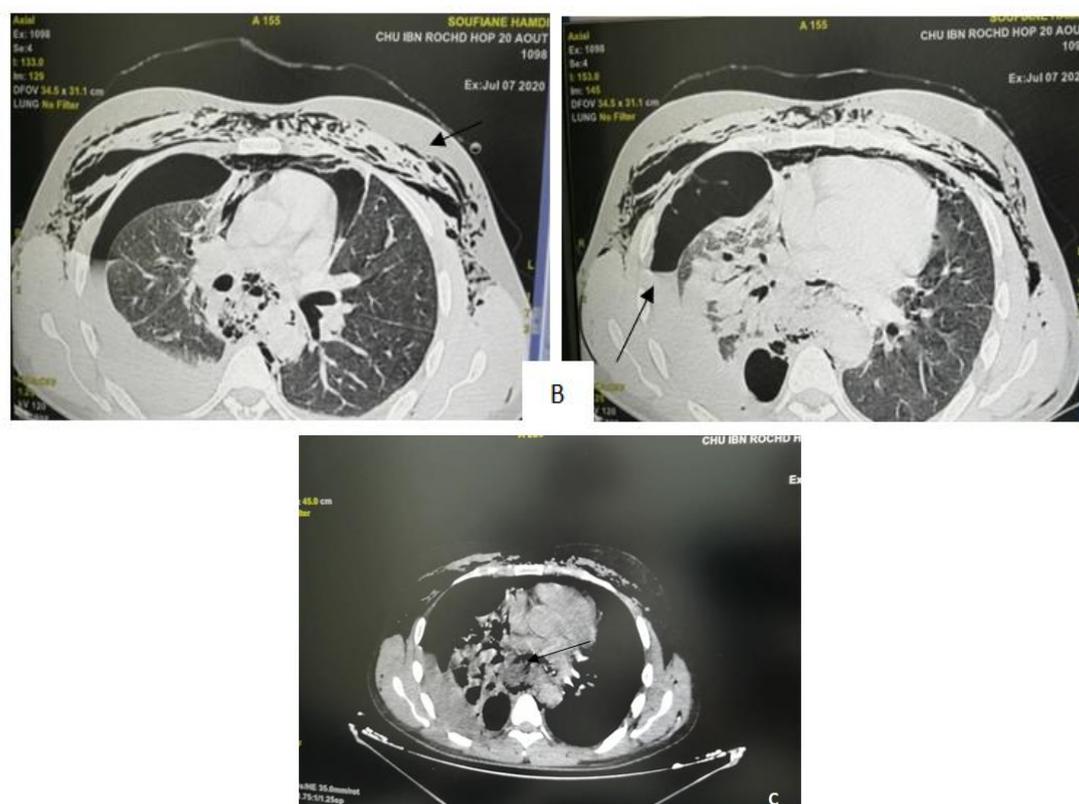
Thoracic computed tomography in parenchymal window (B) confirmed right hydropneumothorax with pneumomediastinum and subcutaneous emphysema Mediastinal window (C) distanciation of the thoracal esophagus
